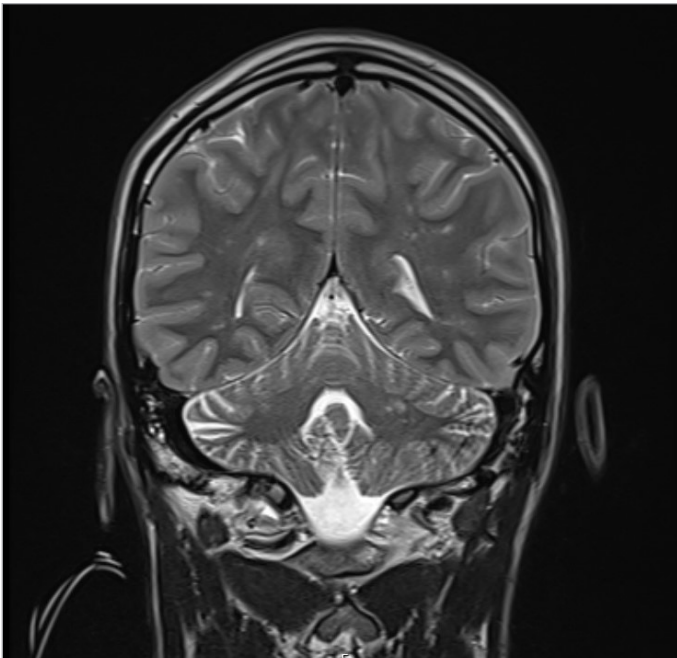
Image of the lesions in the MRI
